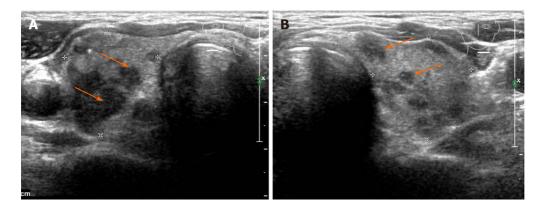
Right thyroid sonogram. A: Left thyroid sonogram; B: Both A and B show multifocal, hypoechoic, irregular, and calcified nodules in the thyroid gland (orange arrows).
